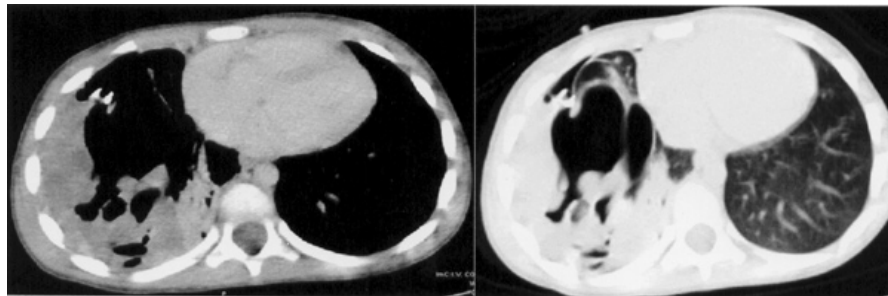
Enhanced CT scan of the chest, mediastinal, and corresponding lung window. A large multilocular cystic lesions containing air and solid areas involving the right lower lobe, and its related pleura. Pleural effusion and chest tube are seen.
